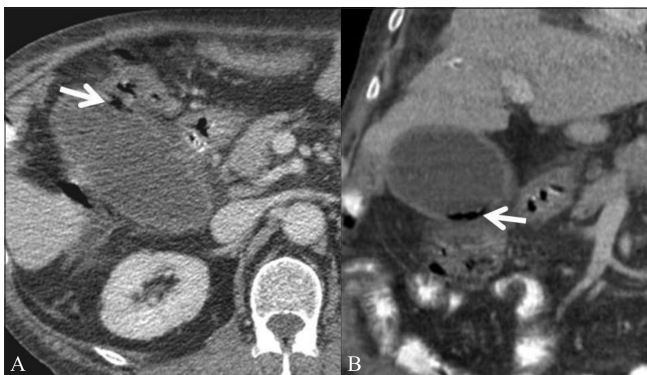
(A,B): Axial CT scan (A) shows an inflamed gall bladder with questionable air in the gall bladder wall (arrow). Coronal reformation (B) confirms air within the gall bladder wall (arrow) suggesting emphysematous cholecystitis
